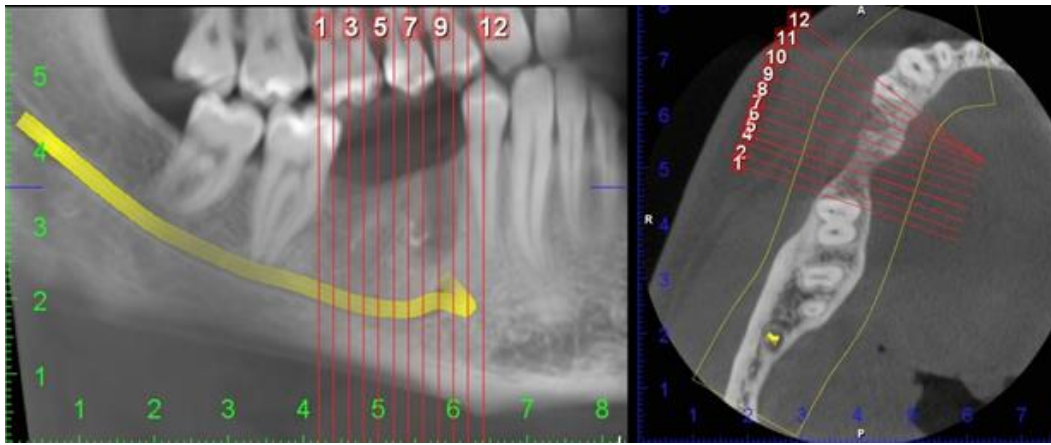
Preoperative CBCT
